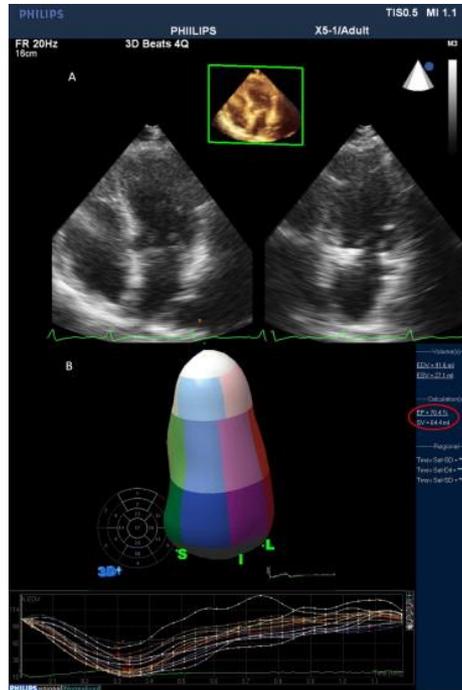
(A) Three-dimensional transthoracic echocardiographic four-heartbeat full-volume acquisition. (B) Left ventricular ejection fraction and stroke volume determination by direct volumetric analysis.
